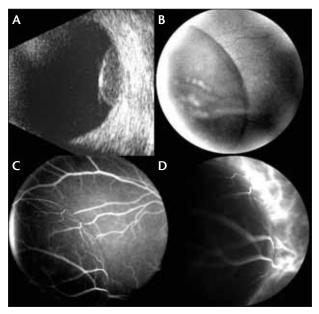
B-scan ultrasound showing acoustic hollowness of the lesion with a dome-shaped configuration (A). Autofluorescence OD with hypofluorescence at the level of the mass (B). Fluorescein angiogram OD in the arteriovenous phase demonstrating hypofluorescence of the lesion temporally without intrinsic vascularity (C). Late phase of indocyanine green angiography with marked hypofluorescence (D).
